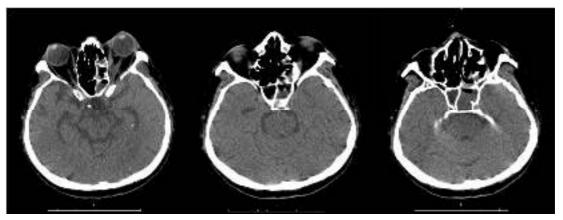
A brain CT scan showed abnormal enhancement in the left orbital apex and opacification of the left sphenoid and ethmoid sinus
